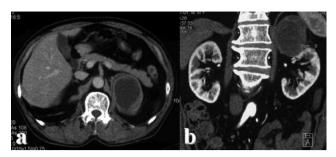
Computed tomography showed a well-defined round, $80 \times 75 \times 60$ mm cystic mass with a rim of soft tissue in the left adrenal region. Slight enhancement of the peripheral rim of soft tissue was seen after intravenous administration of contrast material. (a: Axial image, b: coronal image).
